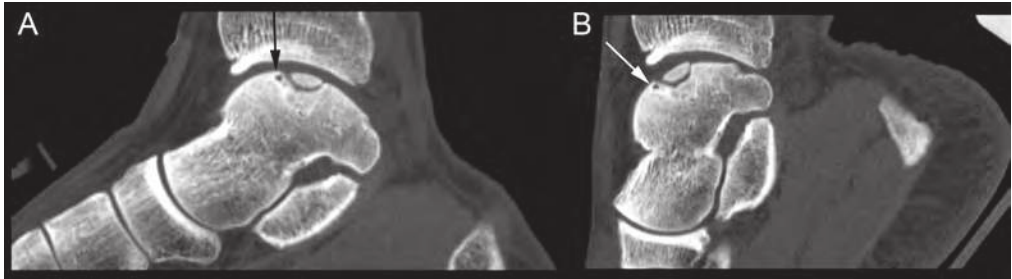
Sagittal reconstructed images of CT scans of an ankle (A) in neutral position and (B) in full plantar flexion. The tube current was 150 mAs for the neutral position and 26 mAs for the plantarflexed position. Although low-dose scans had a lower signal-to-noise ratio, this did not hamper delineation of the defects. The anterior border of the OCD is indicated by the arrows.
